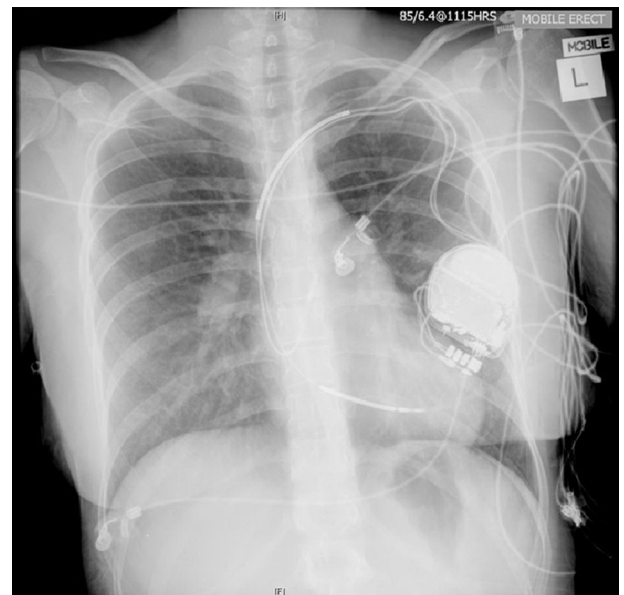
Chest radiograph showing submammary position of implantable cardioverter-defibrillator generator, dual-coil right ventricular shock lead, and right atrial lead.
